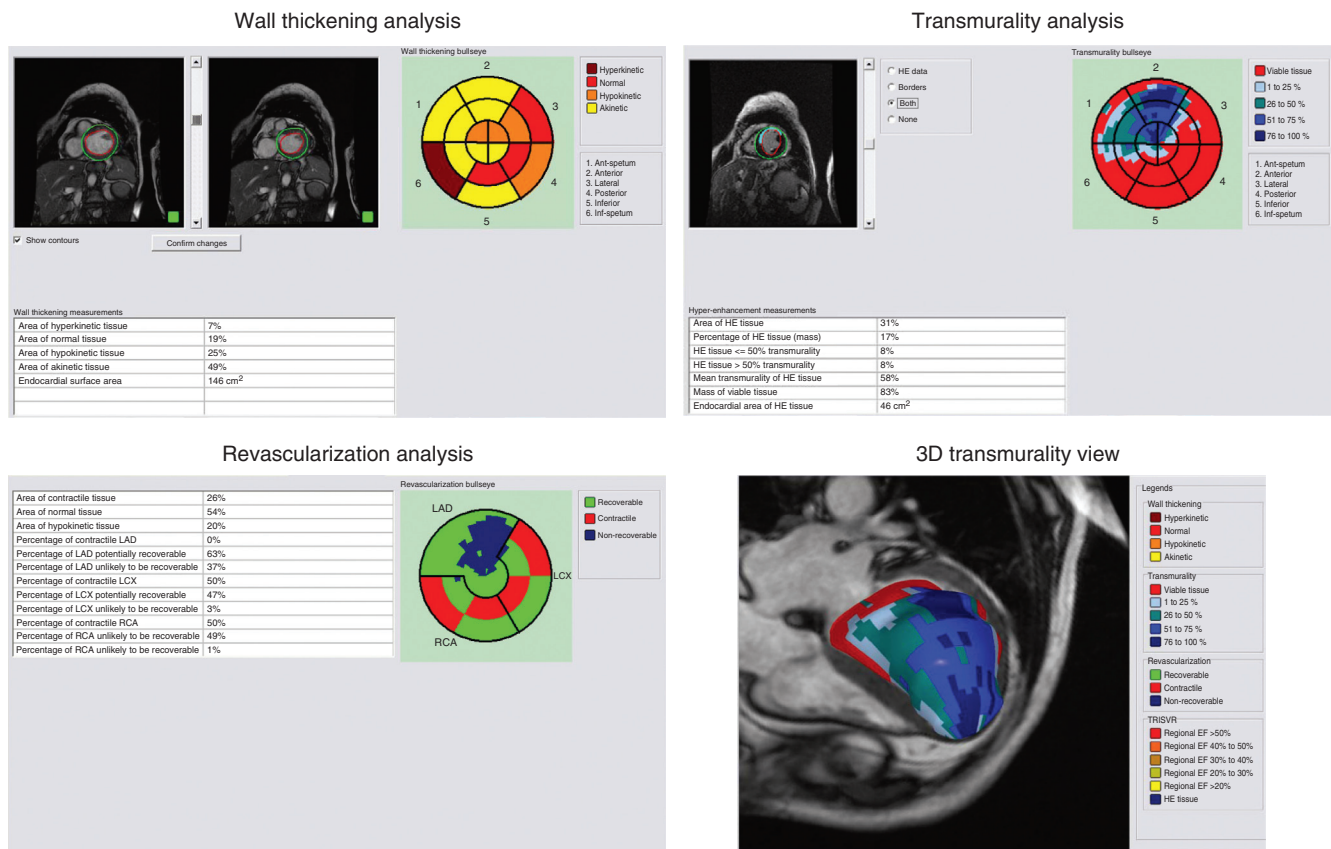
■ Analysis of cardiac function using MARISA software (Magnetic Resonance Imaging System Analysis [Chase Medical, Richardson, Texas]). *Top left*, Wall motion analysis quantified as normal, hyperkinesia, hypokinesia, and akinesia. The percentage distribution of asynergy is calculated. *Top right*, Assessment of scar transmurality with late gadolinium enhancement. The extent of the transmurality from 0% to 100% is color coded, and the percentage of scarred tissue is calculated. *Bottom left*, Analysis of viability: the green area represents potentially viable myocardium that may improve with revascularization; the blue area represents the transmural, nonviable scar. *Bottom right*, Three-dimensional reconstruction of the left ventricle superimposed on the four-chamber view. The extent of the scar as evaluated by late gadolinium enhancement is shown.
